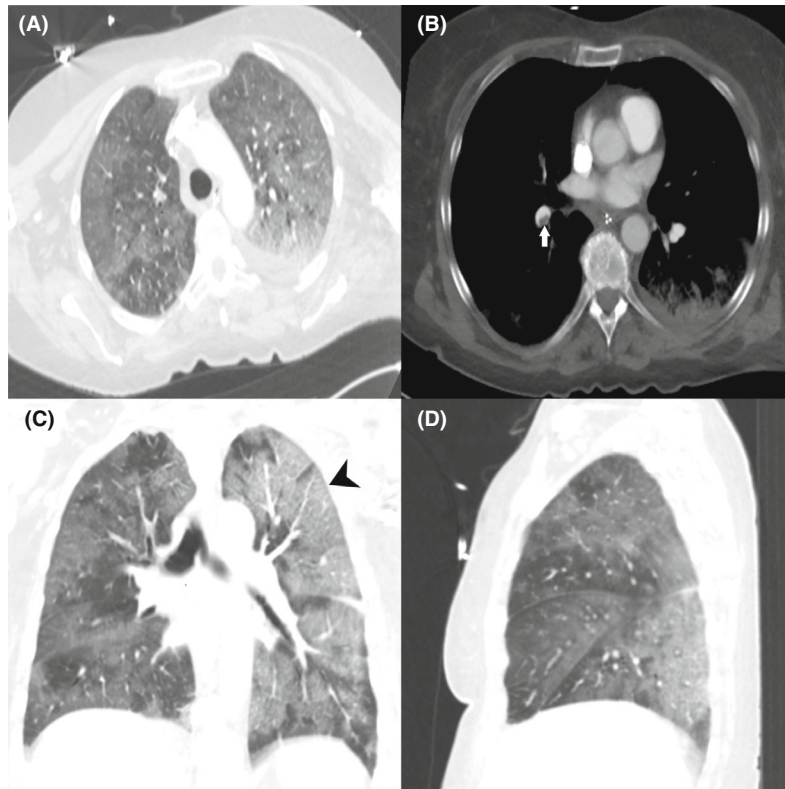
Two weeks after submission with COVID-19. CT thorax in arterial phase: Widespread ground glass bilaterally, with a peripheral distribution. In the left upper lobe, large areas of crazy paving (interlobular septal thickening and ground glass) are seen (C, black arrowhead). Several lung emboli are seen in lobar and segmental arteries (B, white arrow). The overall image is consistent with subacute COVID-19 infection complicated with lung emboli. (A) Axial lung window, (B) axial soft tissue window, (C) coronal lung window and (D) sagittal lung window.
